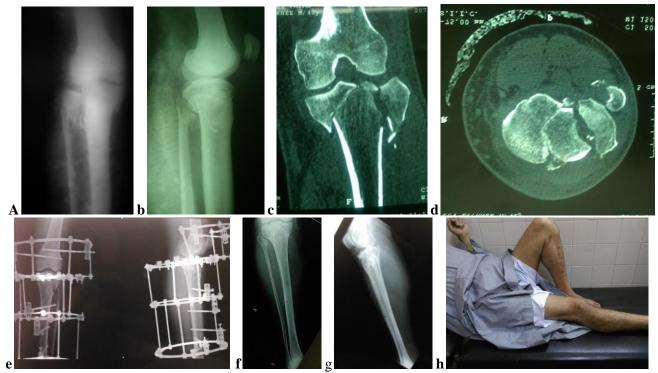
a. anteroposterior view x-ray of bicondylar tibial plateau fracture, lateral x-ray view, c,d. CT scan of the fracture, e. postoperative x-ray fixation by Ilizarov, f,g. after frame removal and h. clinical photo of knee flexion of the patient on follow-up
